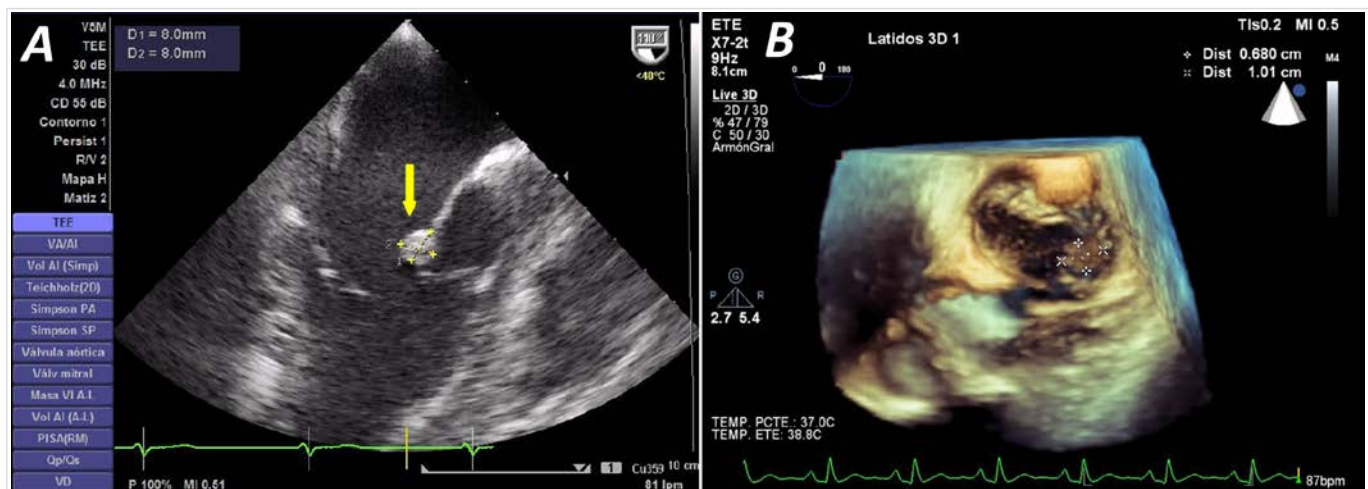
Transesophageal echocardiogram. A. Midesophageal long-axis view of the left ventricle. The nearly 8 × 8 mm mass is observed on the anterior mitral leaflet (arrow); it is not pedunculated, nor does it infiltrate the leaflet. B. Three-dimensional (3D) echocardiography. Left atrial visualization of the mitral valve was similar to that viewed during surgery. A mass on the atrial side of A1, —measuring approximately 10 × 7 mm— is seen.
